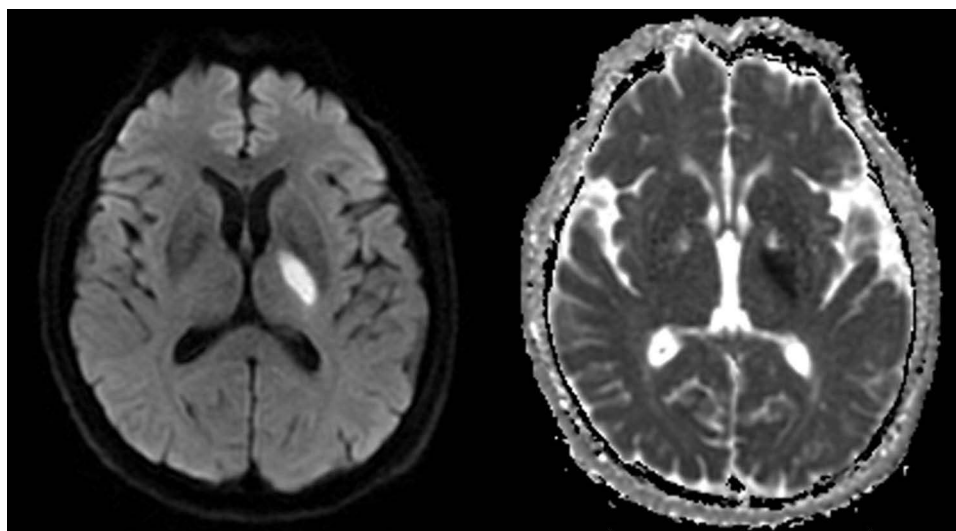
MRI of a new infarction in basal ganglia regions.
